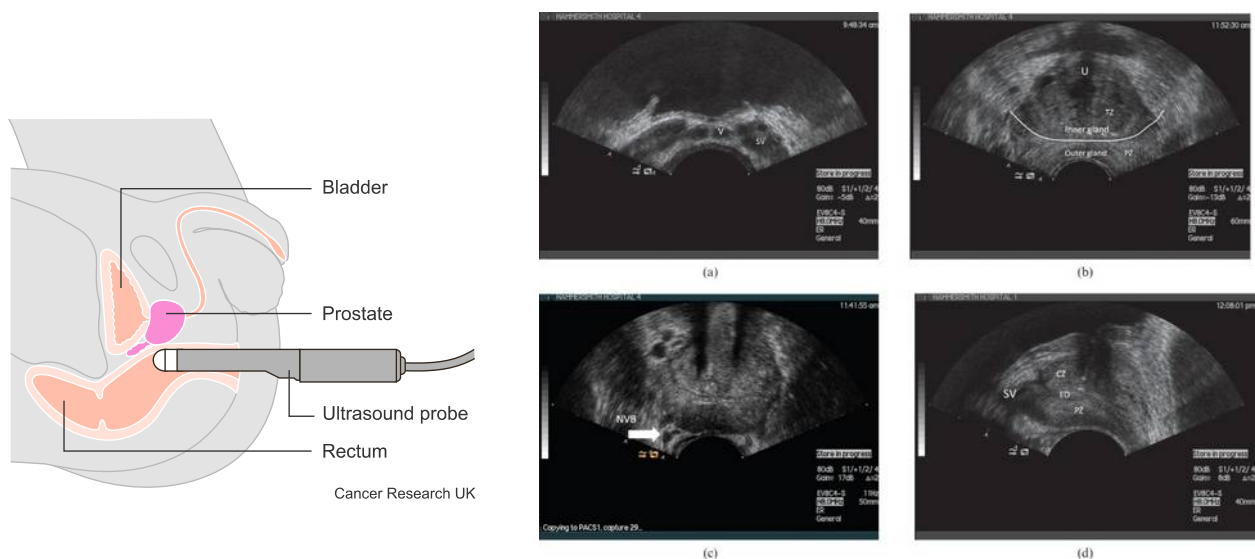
Left. Sagittal plane of a man's pelvis. The probe is introduced into the rectum and the prostate is situated over it (ventrally) (pink)⁴. Right. Four images of the prostate gland in Axial trans rectal ultrasound (a–c) and longitudinal images of the normal prostate (d). CZ, central zone; ED, ejaculatory duct; NVB, neurovascular bundle; PZ, peripheral zone; SV, seminal vesicle; TZ transition zone; U, urethra; V, vas deferens¹⁸
